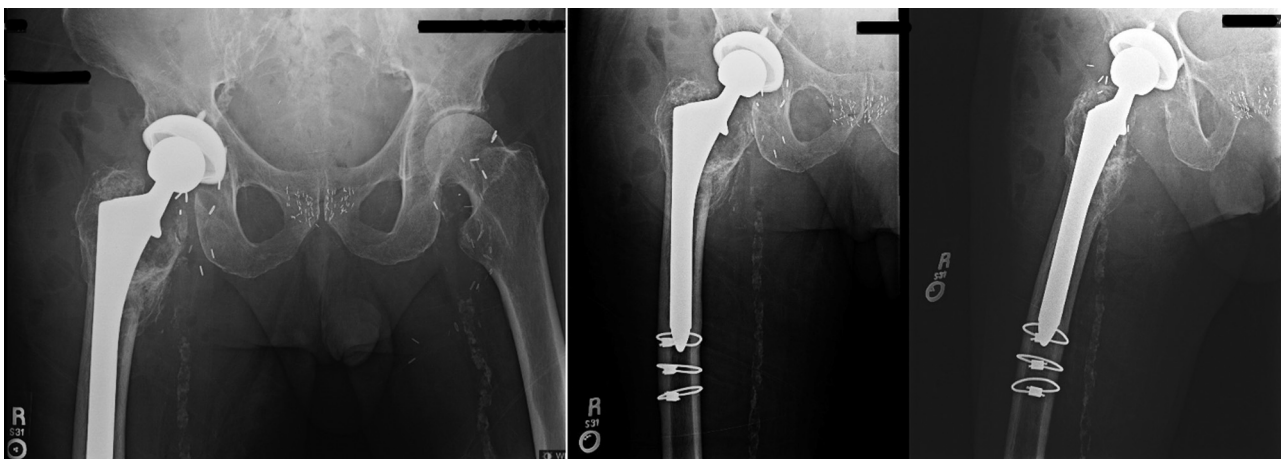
Preoperative radiographs showing well-fixed and well-aligned uncemented right total hip arthroplasty with fully porous coated cylindrical stem. Note extensive proximal femoral osteolysis and cerclage cables at distal extent of stem from index procedure.
